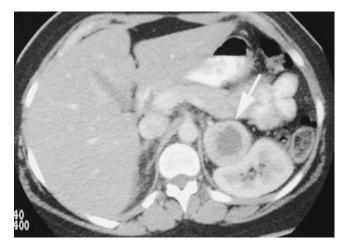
Abdominal computed tomographic scan in a 30-yearold woman with multiple endocrine neoplasia type IIA showing a left adrenal pheochromocytoma (*arrow*) with characteristic central necrosis. Courtesy of Quan-Yang Duh, MD.
